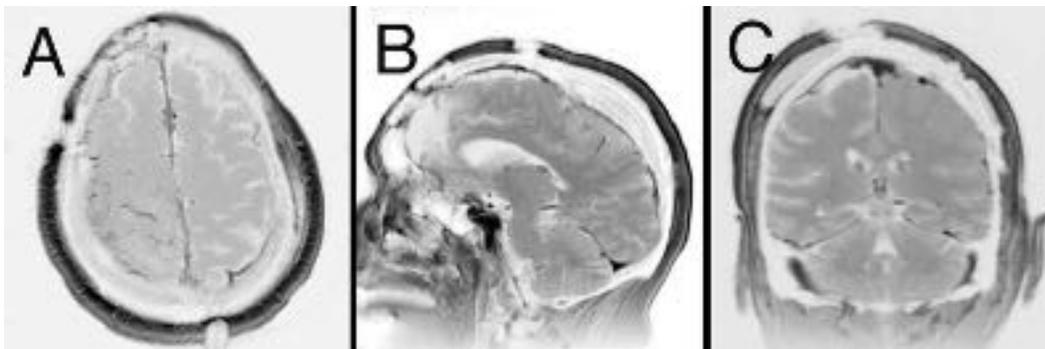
(A) Postoperative axial, (B) sagittal, and (C) coronal magnetic resonance imaging show Simpson grade III resection with a small amount of residual tumor filling and partially occluding the superior sagittal sinus.
